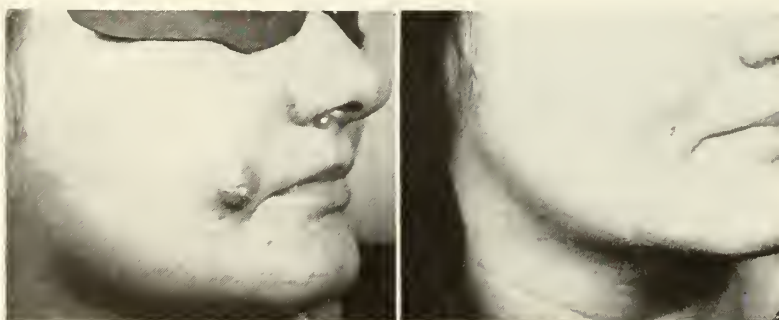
G. W. R. (Case 11), white female, age forty-two. Infected mole on right cheek with enlarged cervical glands. There was a history that suggested possible malignant changes. Five doses of 700 r of X-rays were given on alternate days.
